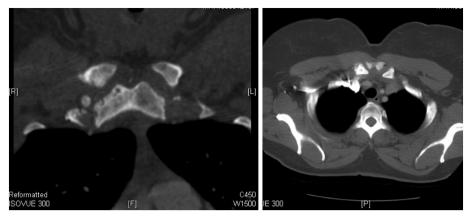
Neck CT scan 6 months postoperatively demonstrating erosive changes similar to immediate postoperative neck CT scan.
